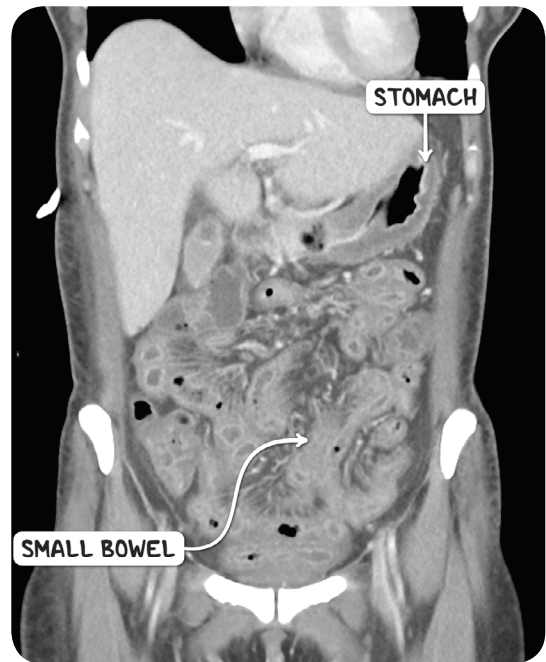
A CT scan in the coronal plane of the abdomen of an individual with graft-versus-host disease. The gastrointestinal tract, including the stomach and small bowel, is grossly edematous.
